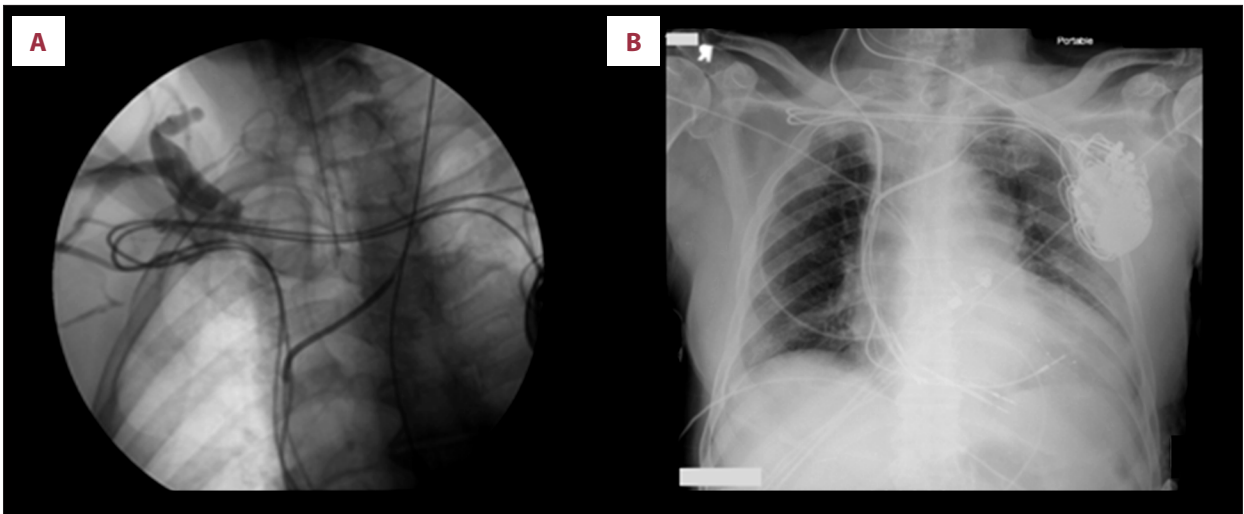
Case 1: (A) Venography of the right upper extremity showing total occlusion of subclavian vein. (B) Chest x-ray posteroanterior (PA) view: Biventricular pacemaker placed via right external jugular vein with right ventricle (RV) and coronary sinus (CS) leads tunneled to the left subclavian pocket.
